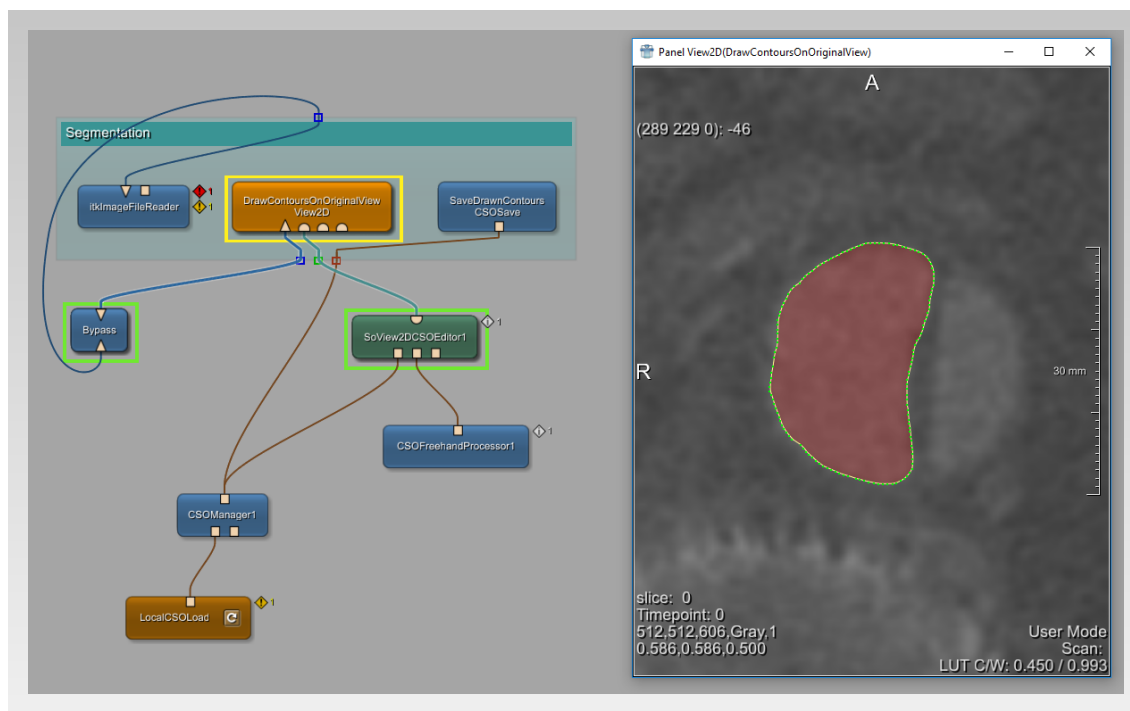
Using a MeVisLab network, the true lumen of the aorta is segmented manually in an axial slice of a patients CT scan.
